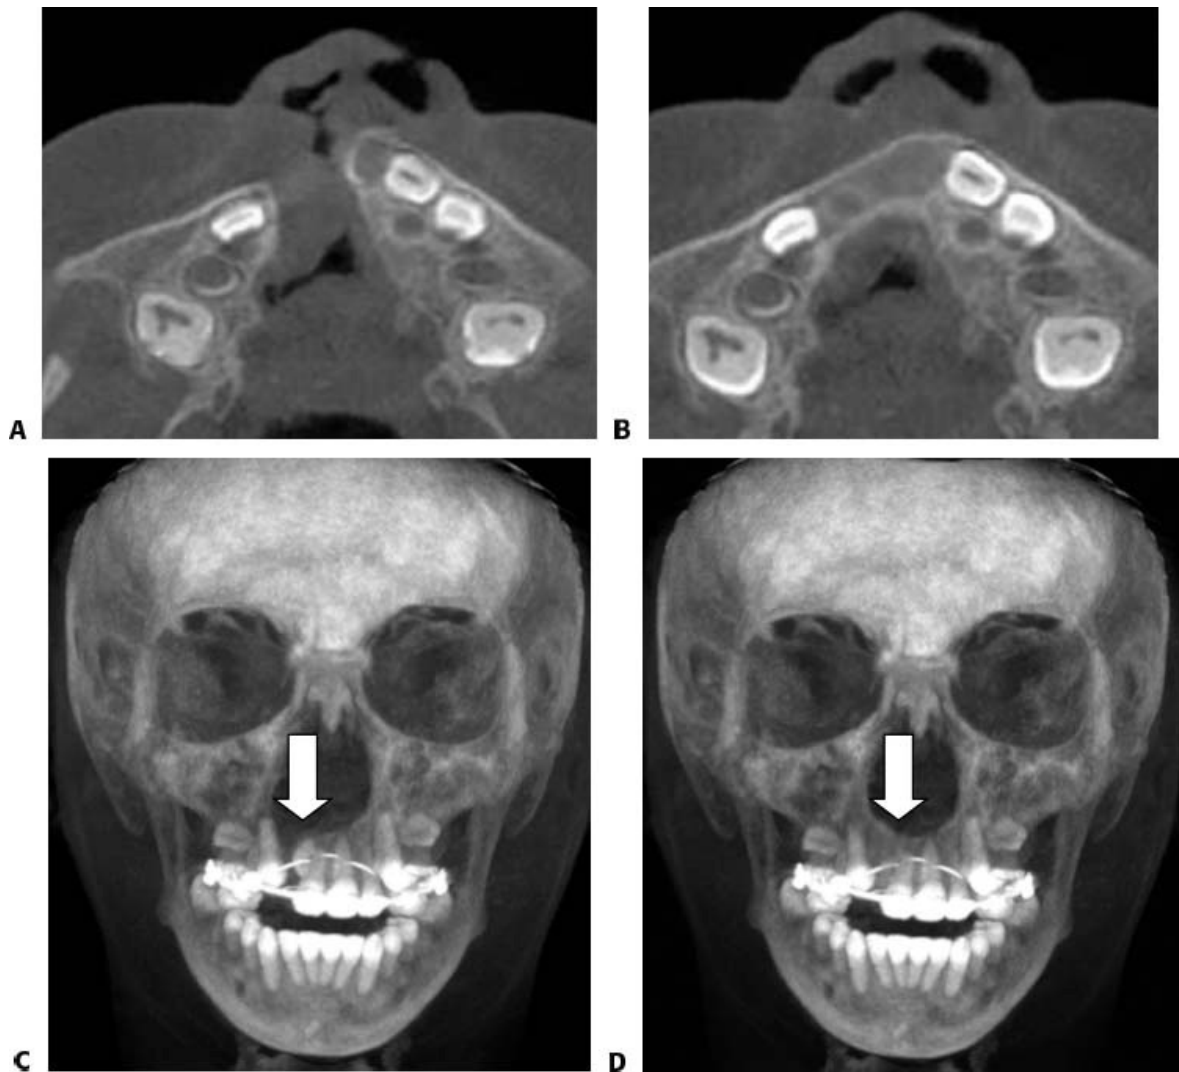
• CT scan with axillary cuts of a patient with right cleft lip and palate. A. Preoperative image shows the alveolar defect. B. Postoperative image 6 months after gingivoperiosteoplasty (GPP) and BMP-2 grafting shows bony healing and closure of the alveolar defect. 3D CT scan of a patient with right cleft lip and palate. C. Preoperative image shows the alveolar defect. D. Postoperative image 6 months after GPP and BMP-2 grafting shows bony healing and closure of alveolar defect.
